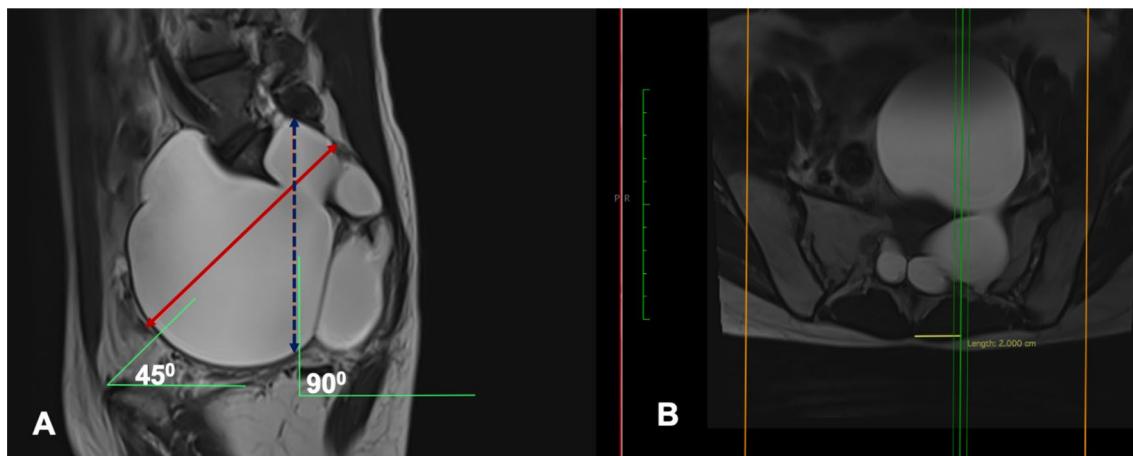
A shows the measurements of Tarlov cyst on MRI in sagittal plane. Dotted arrow represents vertical (Sagittal Craniocaudal) measurements of cyst diameter in 90° in all MRI's. Straight arrow represents
